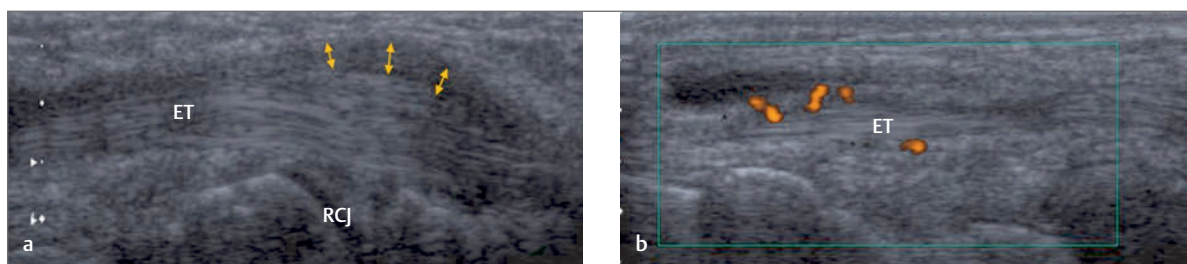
(a,b) Longitudinal images of the fourth dorsal compartment at the level of the radiocarpal joint (RCJ). The extensor tendons (ET) themselves appear intact. However, there appears to be marked thickening of the extensor retinaculum (*double-headed yellow arrows*). In addition, Power Doppler imaging demonstrates evidence of an associated tenosynovitis.
